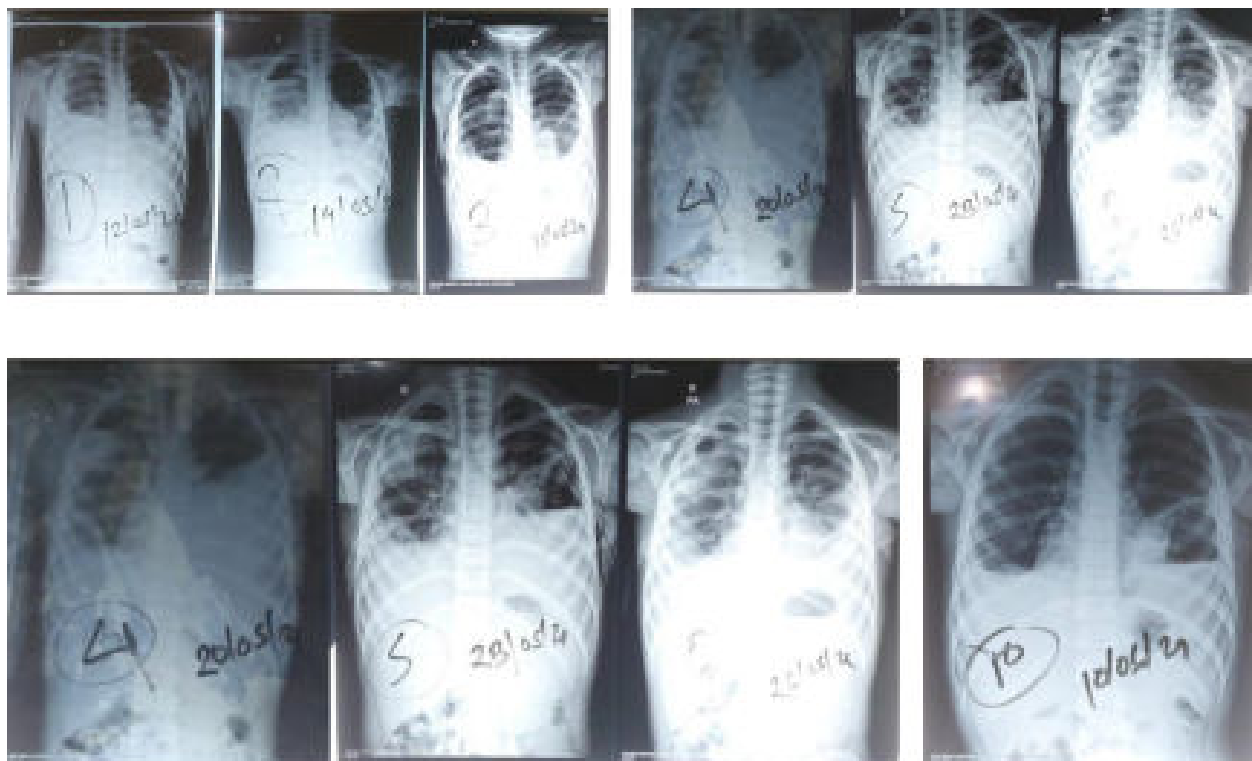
Shows ten consecutive chest x-ray report of the patient starting from the day of admission.
